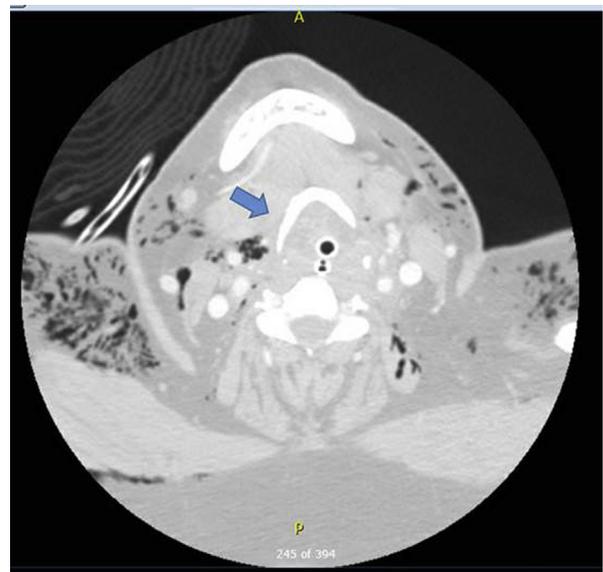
Computed tomography of the neck, demonstrating deviation of the airway to the left with asymmetric emphysema, despite prior decompression before transfer.
